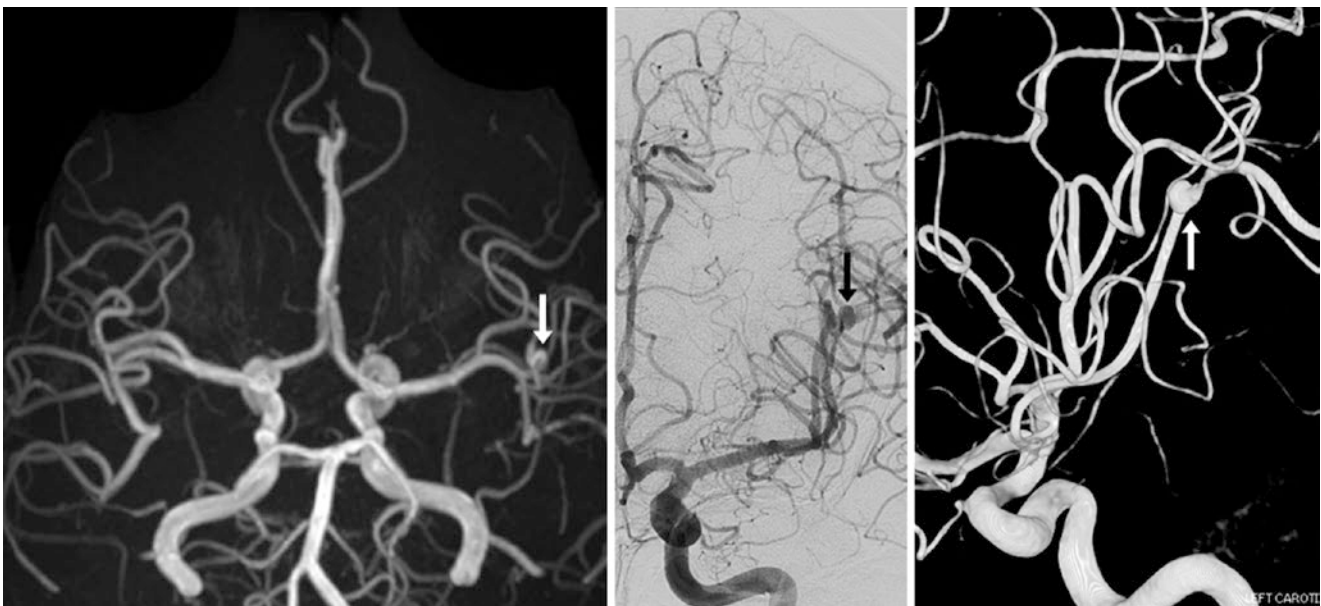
Comparison Case of Mycotic Aneurysm. 26-year-old with a tiny subarachnoid hemorrhage in the left sylvian fissure and an infarct on DWI MRI (not shown). A 3D TOF MRA AP view (left) found a small left MCA outpouching (arrow) of a distal M2 segment, suspicious for
